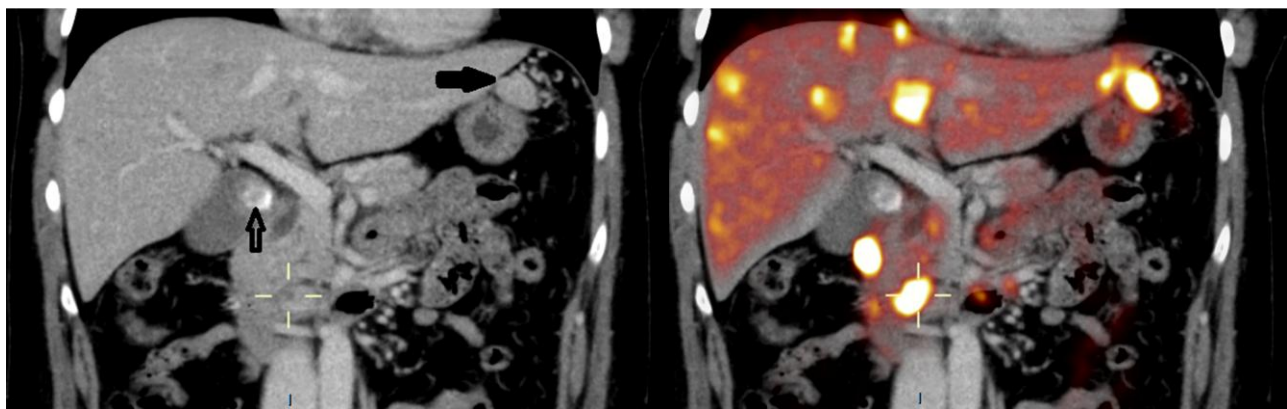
Left: coronal CT image of a 50-year-old woman with documented endogenous hyperinsulinemic hypoglycemia (case 2) showing a 14 \times 15-mm pancreatic lesion (box) and a gallbladder stone (arrow). Right: coronal ^{68}Ga -DOTATATE PET/CT fused images of a 50-year-old woman with documented endogenous hyperinsulinemic hypoglycemia (case 2) in the same plane as Fig. 2A showing a 14 \times 15-mm PET-positive pancreatic lesion (box) and extensive ^{68}Ga -DOTATATE PET-positive liver metastases.
